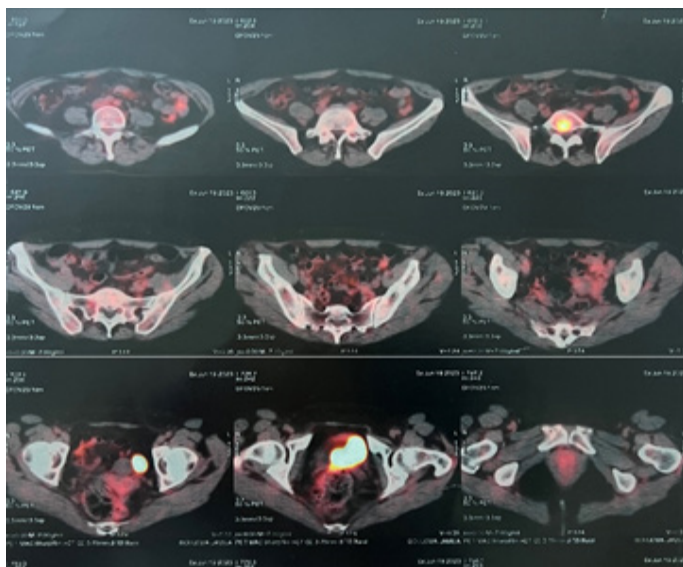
PET/CT with 18F-FDG at initial staging.
